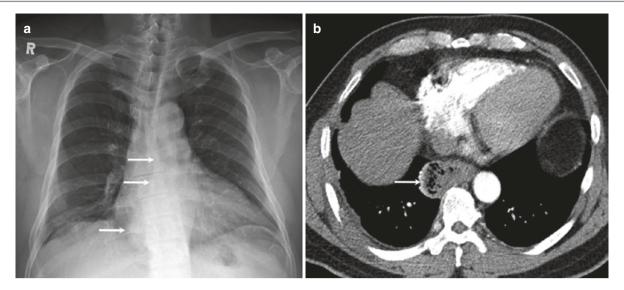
53-year-old woman with an epiphrenic diverticulum. (a) Frontal radiograph shows displacement of azygoesophageal recess (arrows). (b) Axial CT image demonstrates the epiphrenic diverticulum (arrow)
